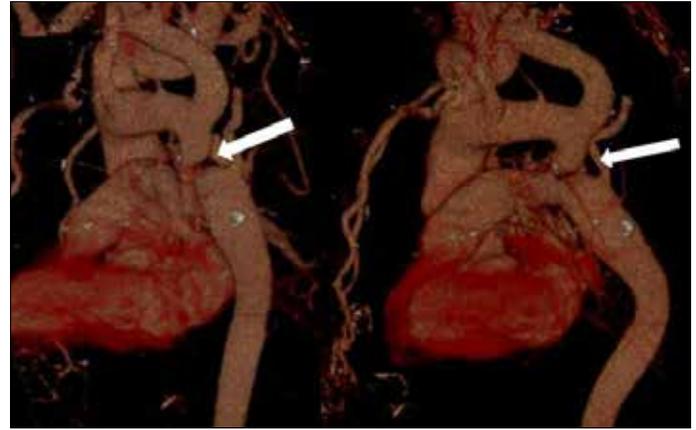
Multislice computed tomography angiography views of aortic coarctation in different positions
